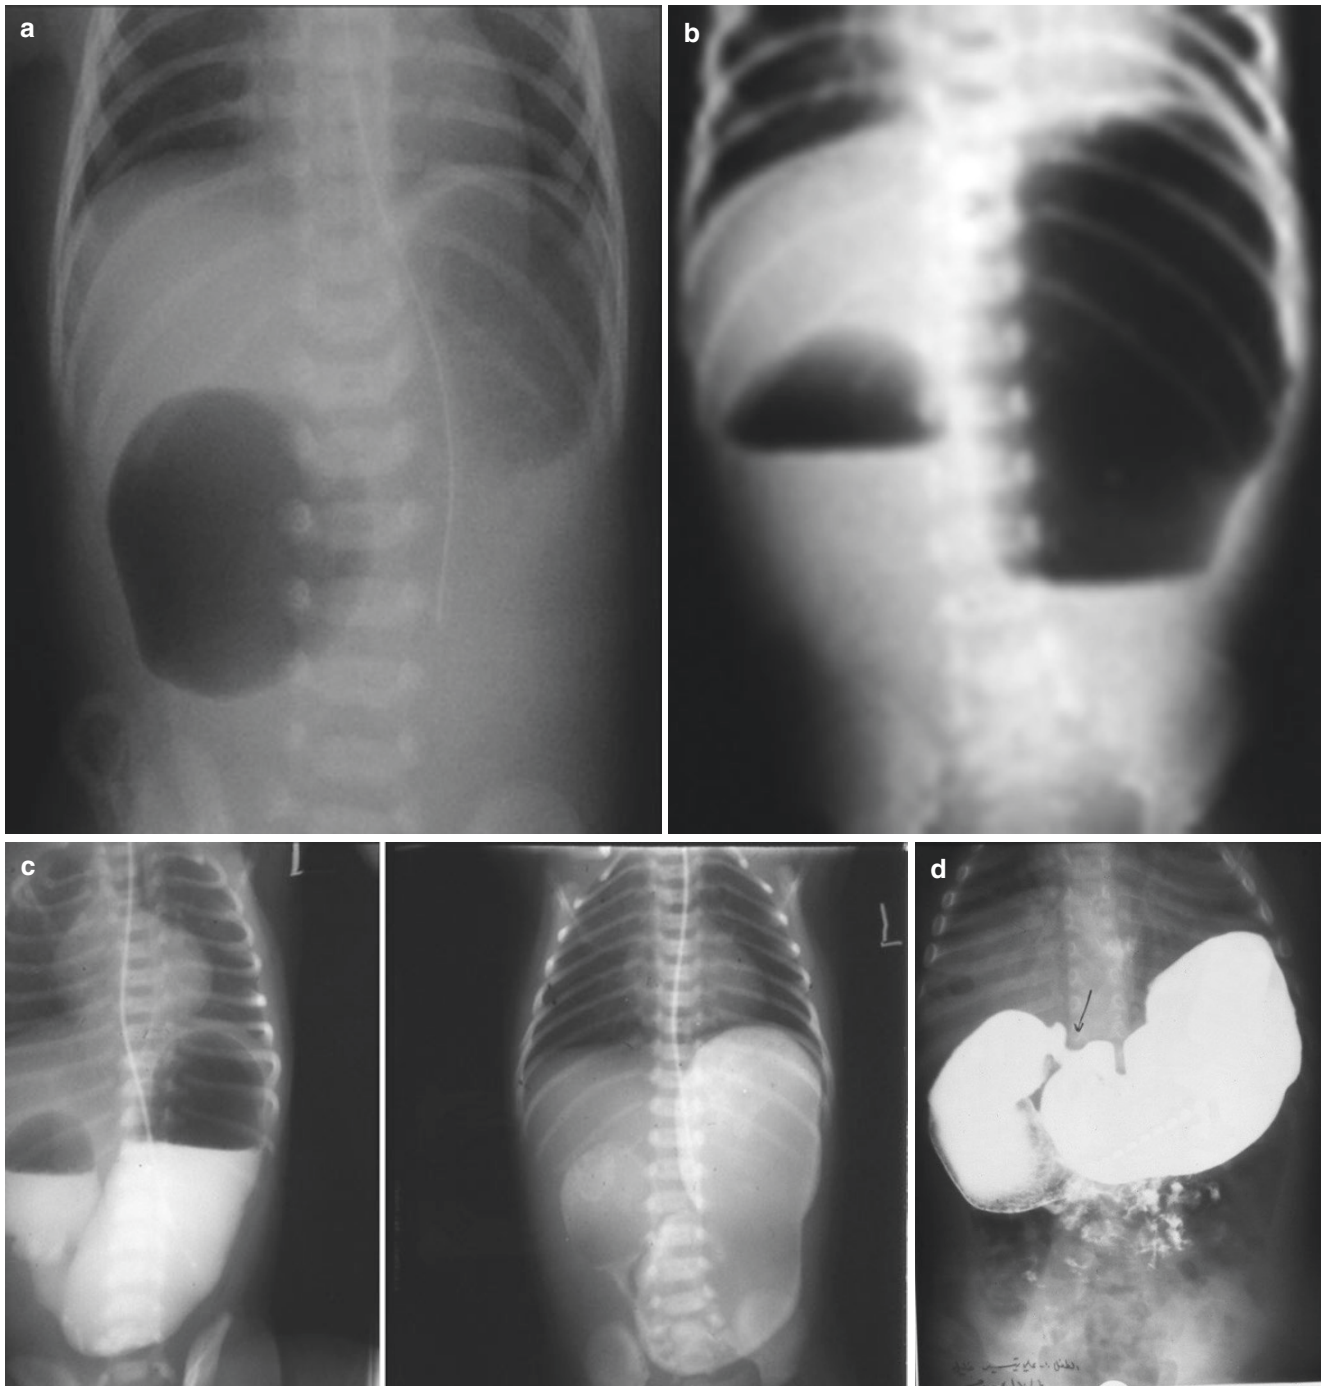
(a) Plain X-ray of a neonate with duodenal atresia showing a double bubble: one bubble in the dilated stomach and the other in a dilated proximal duodenum at the level of the obstruction. There is a nasogastric tube in situ. The rest of the abdomen is gasless. (b) Duodenal atresia seen in an erect film showing the fluid air interface of the two bubbles of gas. (c) Duodenal atresia. This is a historic figure showing contrast in the stomach, which is grossly dilated, and in the duodenum. A nasogastric tube is in situ to aspirate the contrast. This study is no longer recommended. (d) A contrast study showing a duodenal stenosis/web with incomplete obstruction and contrast passing distally. The duodenum is large, as is the stomach, due to the obstruction. There is
